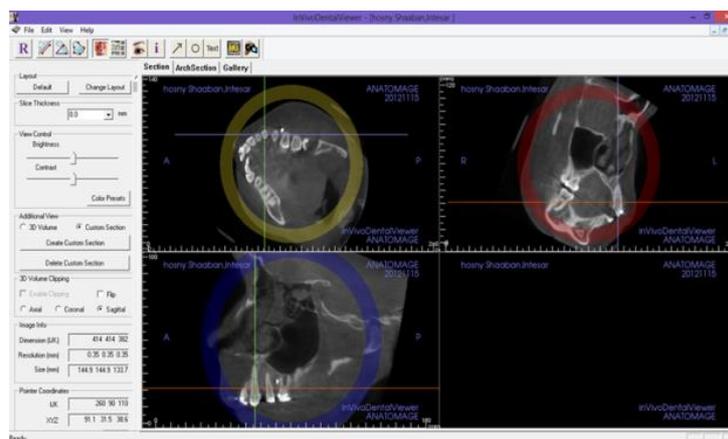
Orientation of the CBCT for measurement
